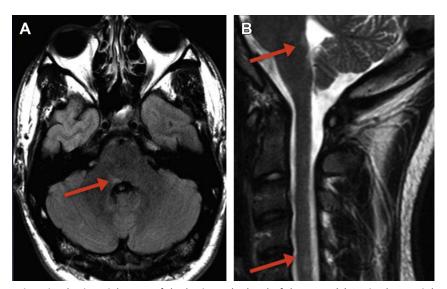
(A) MR imaging brain-axial FLAIR of the brain at the level of the pons. (B) Sagittal T2-weighted image of the cervical spine in a 23-year-old man presenting with binocular diplopia involving right CN VI. Arrows denote the FLAIR and T2 hyperintensity at the level of the right CN VI nucleus, just anterior to the fourth ventricle, in patient with demyelinating disease. Second arrow more inferiorly on the T2-weighted MR imaging demonstrates an additional demyelinating plaque in the cervical spinal cord.
